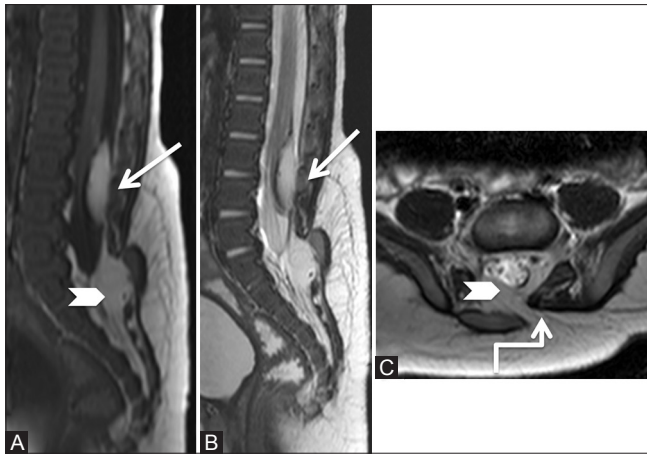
(A-C): Benign lesions: Lipoma: 3-month-old male child had a soft swelling over the lower back since birth. Sagittal T1-weighted (A), T2-weighted (B), and axial T2-weighted (C) images showing low lying conus at L3-4 level with intradural lipoma (arrow) adherent to the posterior surface of cord. Spina bifida is seen at S1 level (elbow arrow), and through it, the subcutaneous fat extends into the epidural space (arrowhead). These findings are suggestive of lipomyelocele
